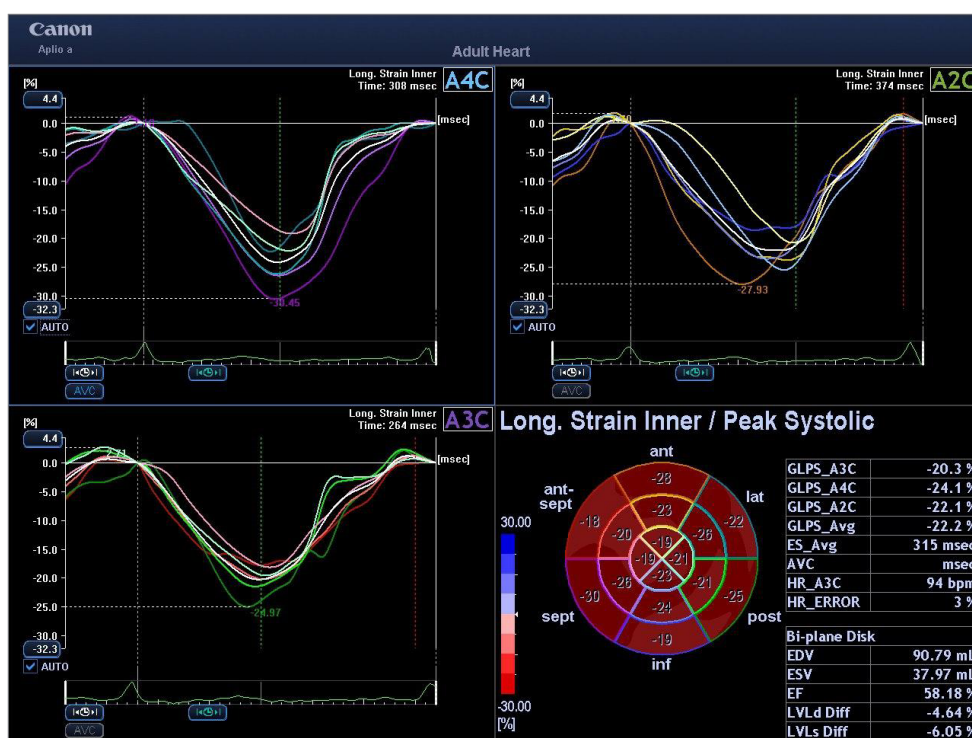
Echocardiography with speckle tracking (ST) at 14-month follow-up. GLS = -22.2 % (preserved)
